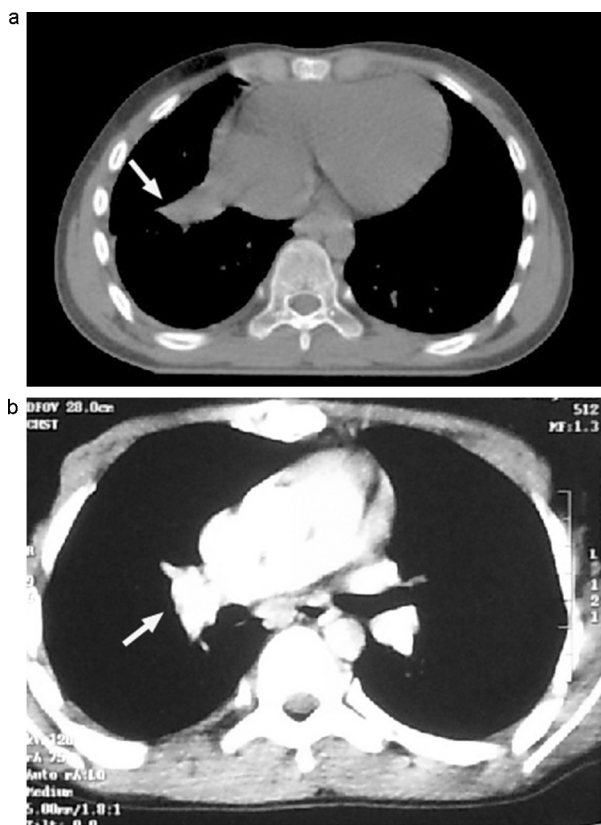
Chest computed tomography (CT) findings. (a) Plain and (b) contrast-enhanced CT image. Intra-pericardial tumor in contact with the right atrium and right ventricle (arrow).
